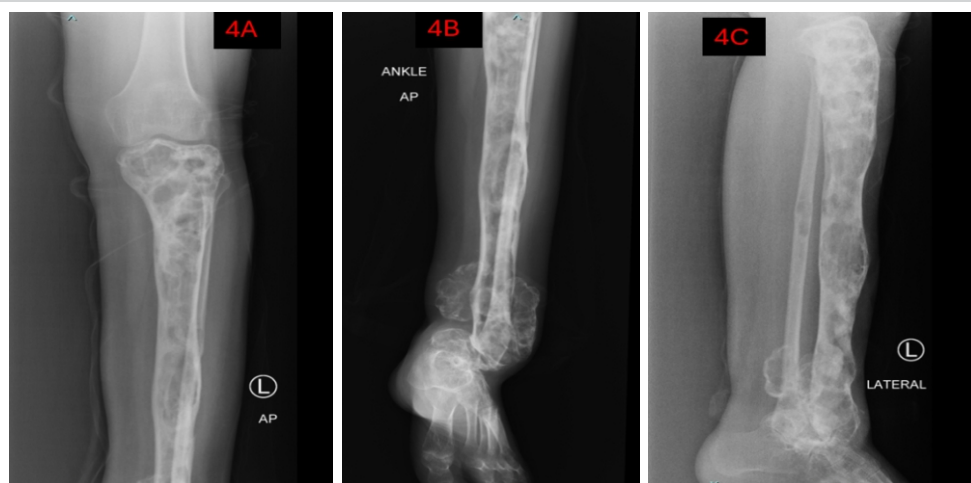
Follow-up radiographs at 24 months. (a,b) Anteroposterior view. (c) Lateral view showing disease stabilization.
